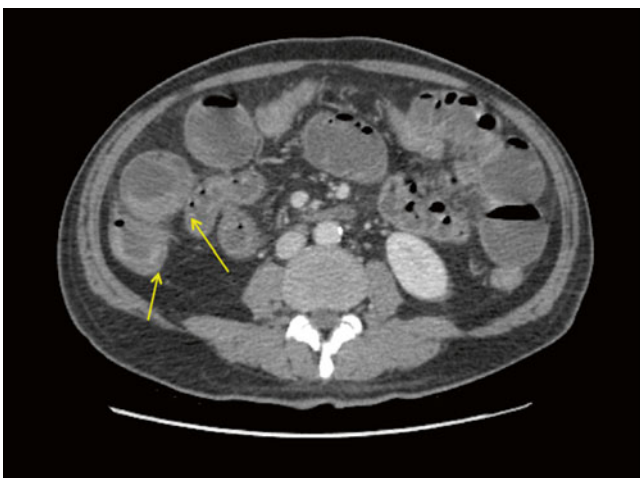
CT—small bowel dilation with diffuse wall thickening and mucosal enhancement in setting of neutropenic enterocolitis
